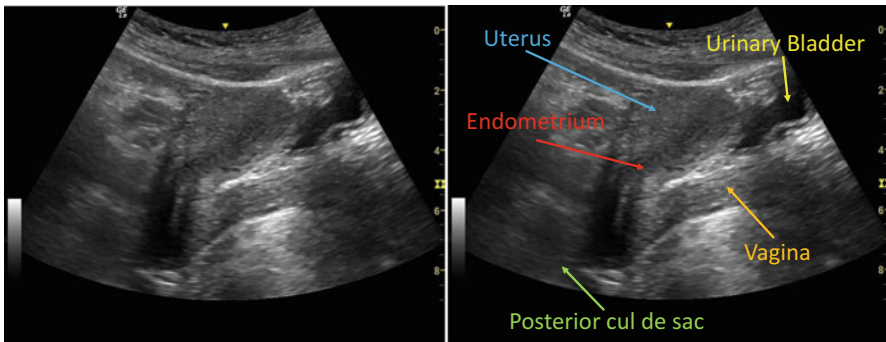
Normal female uterus in the abdominal longitudinal plane. A full urinary bladder will provide an acoustic window to help visualize the uterus abdominally. The uterus appears hypoechoic (darker grey) to the surrounding tissue. Area containing fluid appears anechoic or black on ultrasound. Therefore, the fluid filled urinary bladder appears anechoic (black). The normal uterus during reproductive years is pear shaped and has a body twice the size of the cervix. The outer contour is flat or slightly convex and the inner endometrial cavity contour is flat
